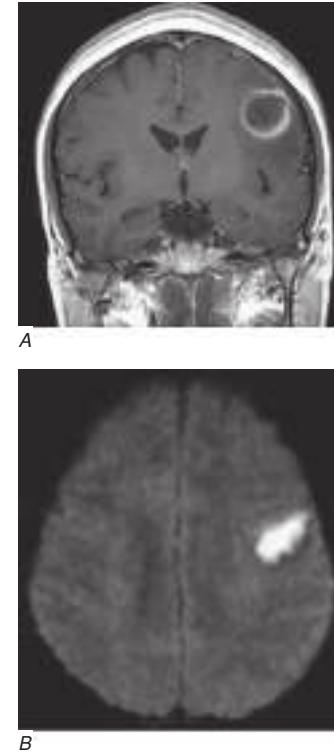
Cerebral abscess in a patient with fever and a right hemiparesis. A. Coronal postcontrast T1-weighted image demonstrates a ring-enhancing mass in the left frontal lobe. B. Axial diffusion-weighted image demonstrates restricted diffusion (high signal intensity) within the lesion, which in this setting is highly suggestive of cerebral abscess.
